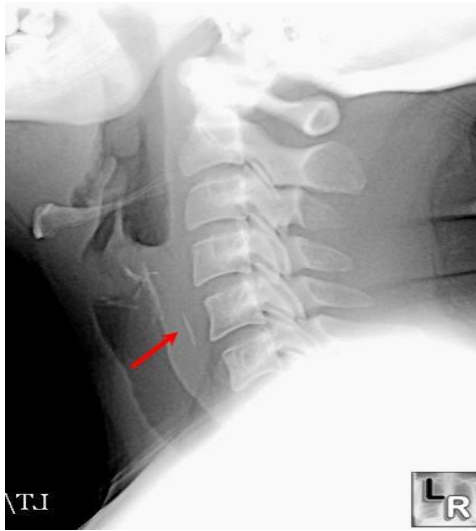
Radiograph of forty years old patient with staple pin in cervical part of esophagus.
